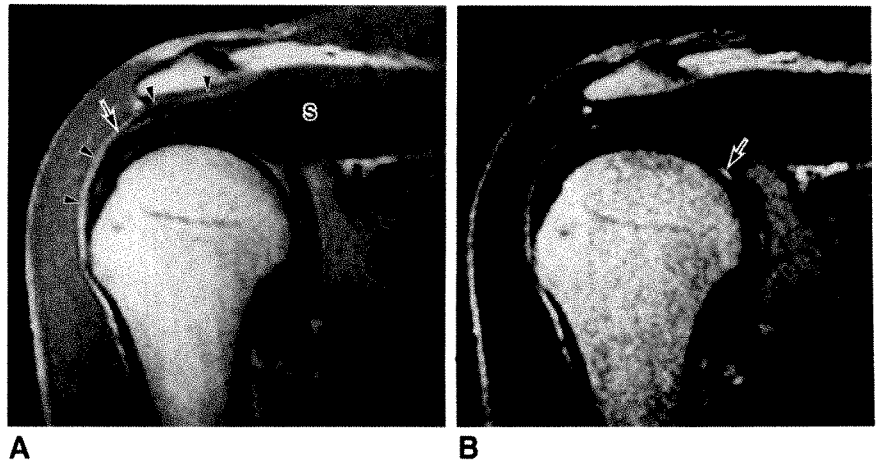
Oblique coronal MR images parallel to axis of glenohumeral joint of right shoulder of a normal 23-year-old volunteer.
